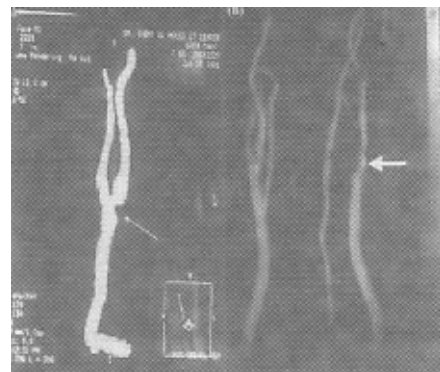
CT angiography showing severe stenosis at the common carotid bifurcation.
